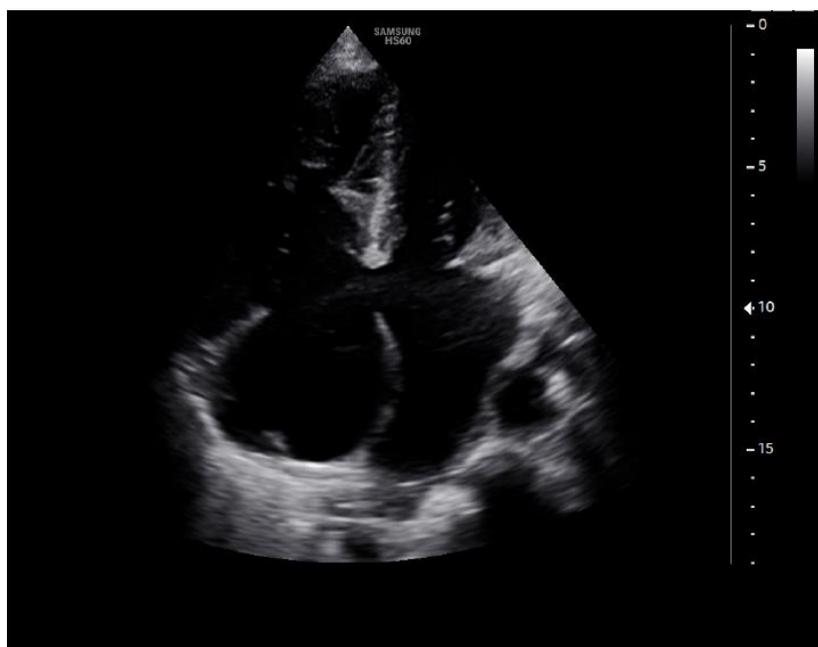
Echocardiography apical 4 chamber view showing the ostium primum ASD and PAVCD
